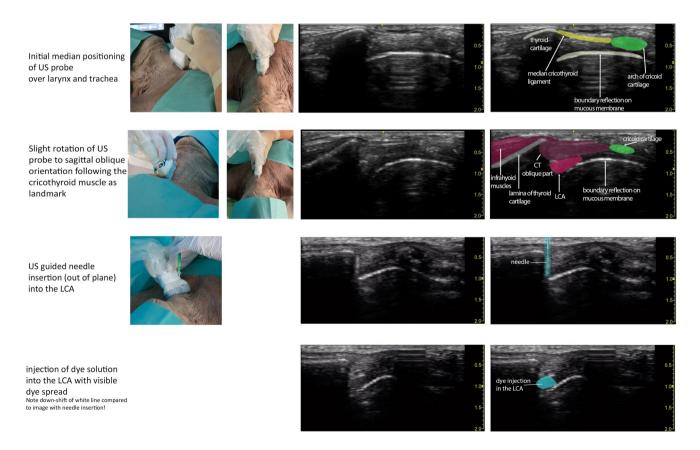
Overview of probe positioning and needle insertion with corresponding ultrasound image
